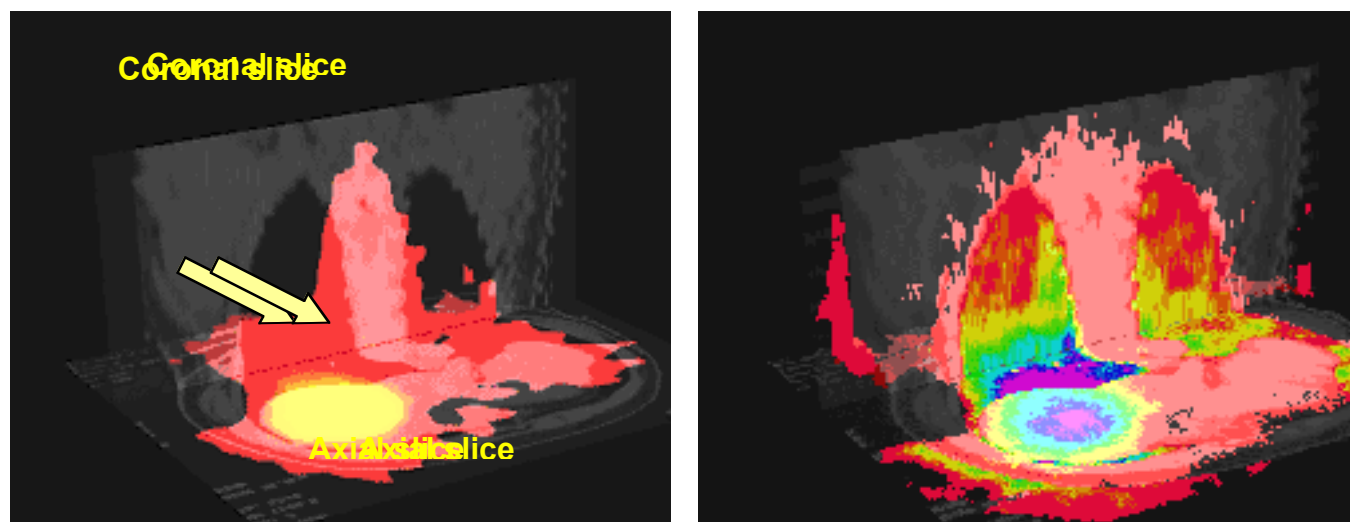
Coronal- and axial-slice views of a fused CT/SPECT image (A) and CT/radiation absorbed dose images (B), shown as a color wash for a patient with advanced breast cancer. For (A), high-low activity is shown by yellow-red-no color. In (B), high-low activity is shown as purple-blue-aqua-green-yellow-red-clear. The high activity in the liver is partially registered in the lower-density lung (see arrow). This results in an erroneously high radiation absorbed dose predicted in the lung, and insufficient activity in the liver. This problem arises because the patient was scanned on different days and different positions: the SPECT was obtained with arms down, while the CT was obtained with arms up.
